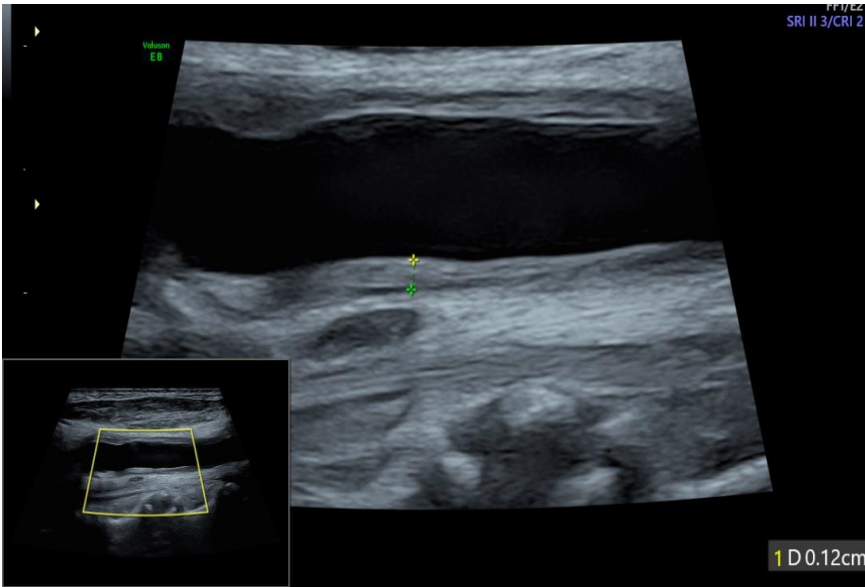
High frequency USG with a linear transducer of frequency range 7.5-12 MHZ to assess carotid artery in the form of intima media, plaque characterisation and doppler assessment of PSV
